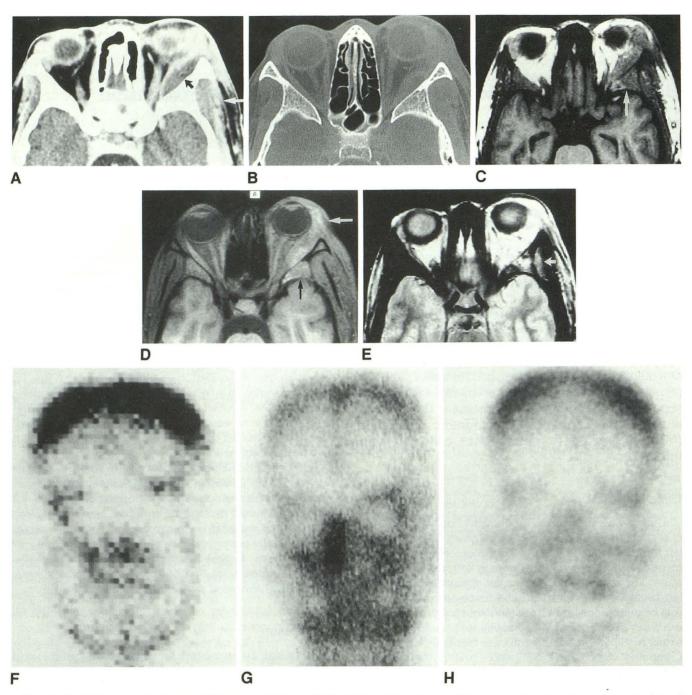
A*, Axial contrast-enhanced CT scan reveals an elliptical-shaped low density (*black arrow*) in the extraconal superolateral aspect of the left orbit that was interpreted as representing a collection. Thickened enhancing tissue is seen on periphery of this low density and anterior to it in the region of the lacrimal gland. In addition, there is swelling and increased density of tissues in the temporalis fossa (*white arrow*).
